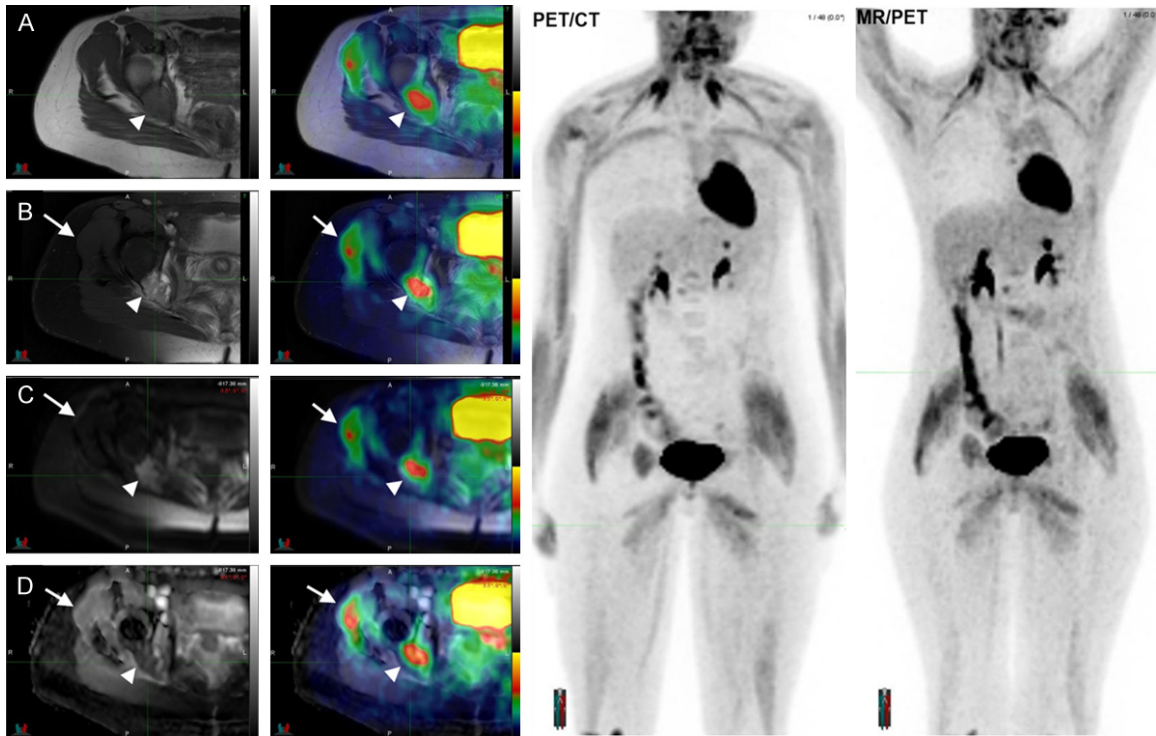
Axial T2w (A), STIR (B), DWI (C) and ADC (D) and the fusion of these images with the corresponding PET shows integration of the PETs functional capabilities with MRIs local assessment of the recurrence (arrow heads). Notice the peri-articular muscle uptake (arrows) which can be discarded as physiological due to the normal appearance of that area in STIR, DWI and ADC images (arrows). Direct comparison of PET MIPs allows recertification of the successful performance of the MR based attenuation correction map.
